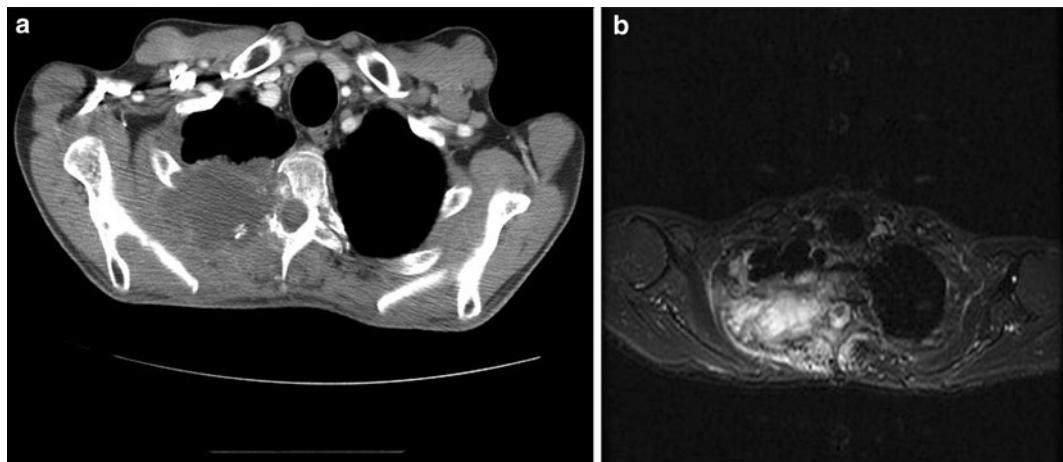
(a, b) Right Pancoast tumor invading chest wall and destroying adjacent vertebral body as shown on CT (a) and MR (b) scans.
